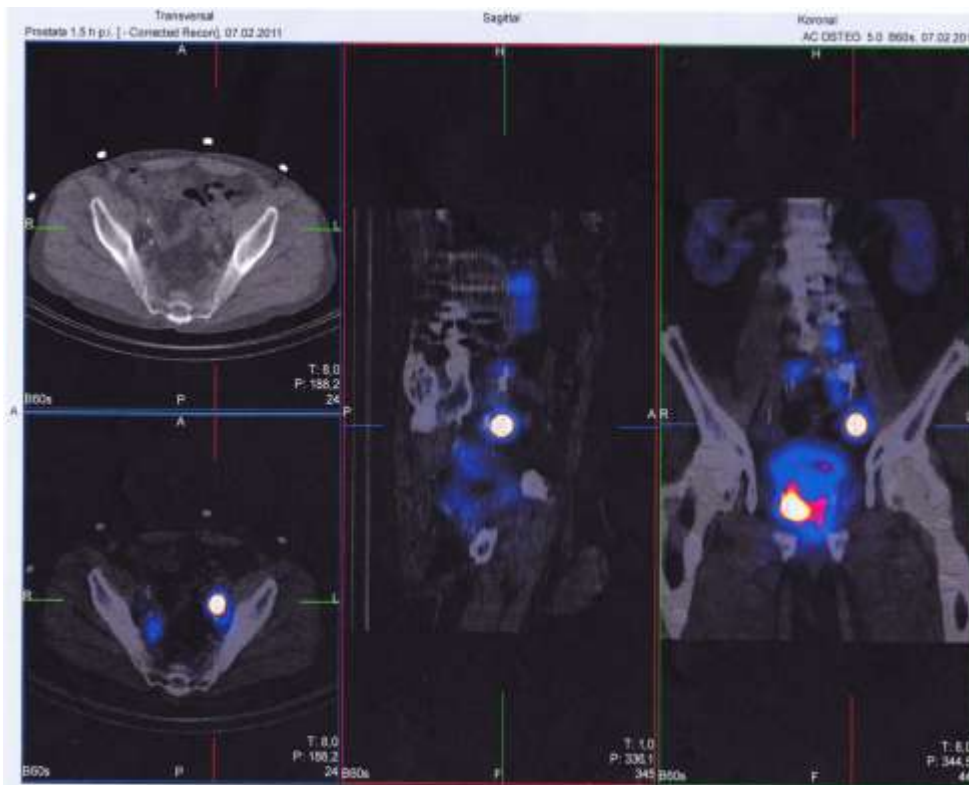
Pelvine scintigramm. Suspicion of left-side pelvine LN metastasis.
